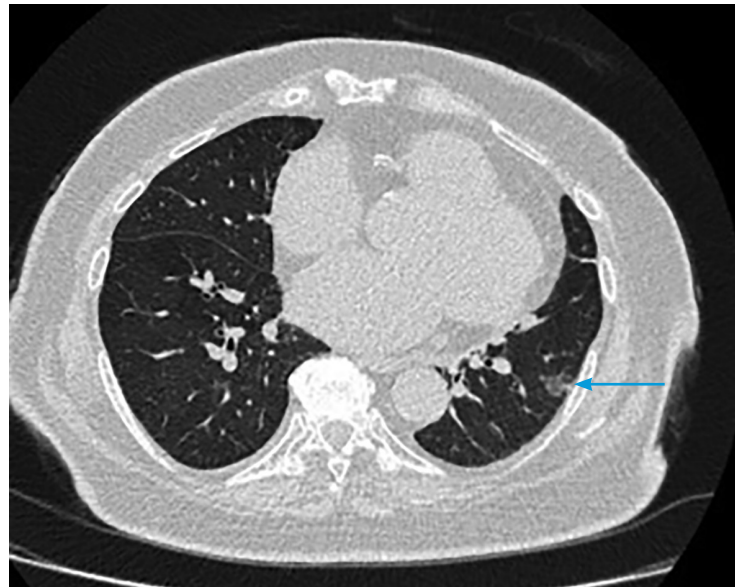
Computed tomography image demonstrating a solitary ground-glass nodule (blue arrow).
